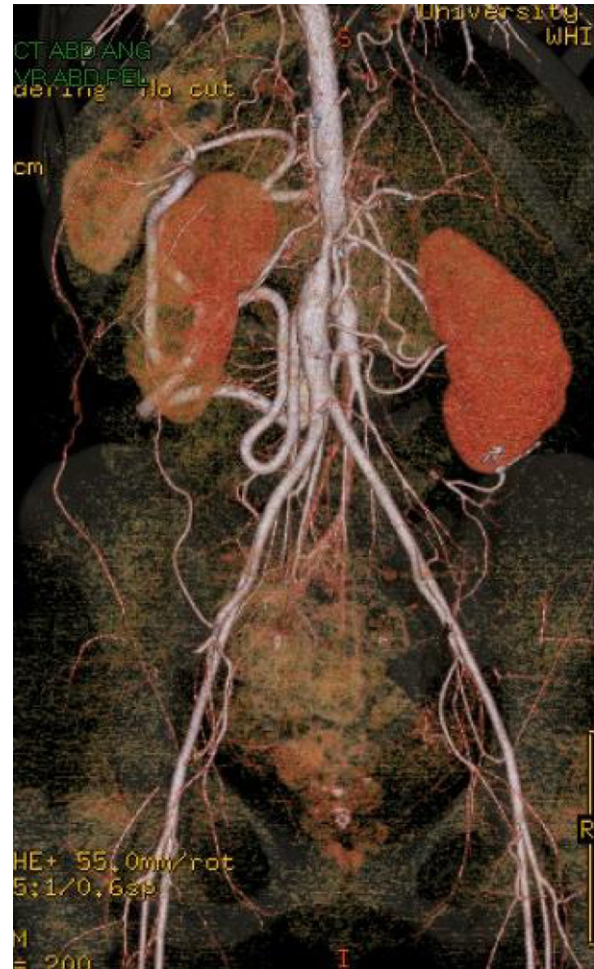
CT arteriogram demonstrating coarctation of the abdominal aorta.
